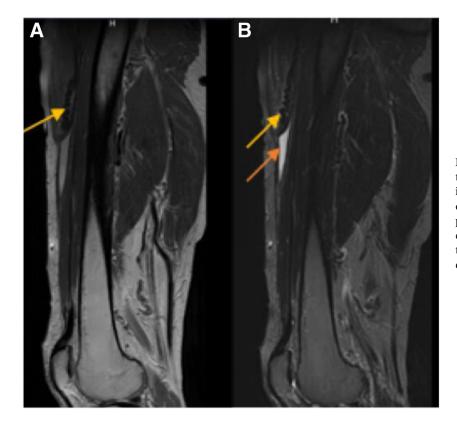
Sagittal magnetic resonance imaging of the right thigh. Plain T2-weighted image (A) indicates the rupture and proximal retraction of the rectus femoris (yellow arrow), and plain short tau inversion recovery image (B) demonstrates both the proximal retraction of the rectus femoris (yellow arrow) and the effusion (orange arrow).
